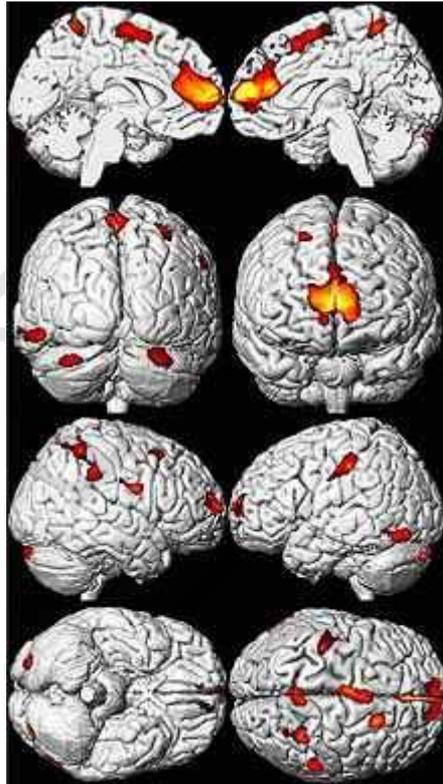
MRI picture of the brain of an adult who exposed to lead during childhood.
